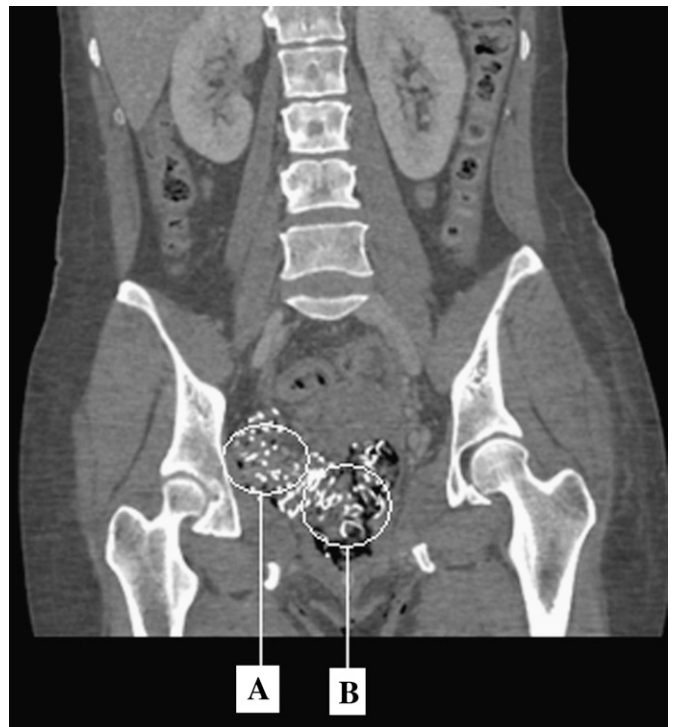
CT Abdomen/Pelvis—Coronal section with Combat Gauze identified in the (A) extravaginal space and (B) vagina. No evidence of retroperitoneal bleed is evident.
